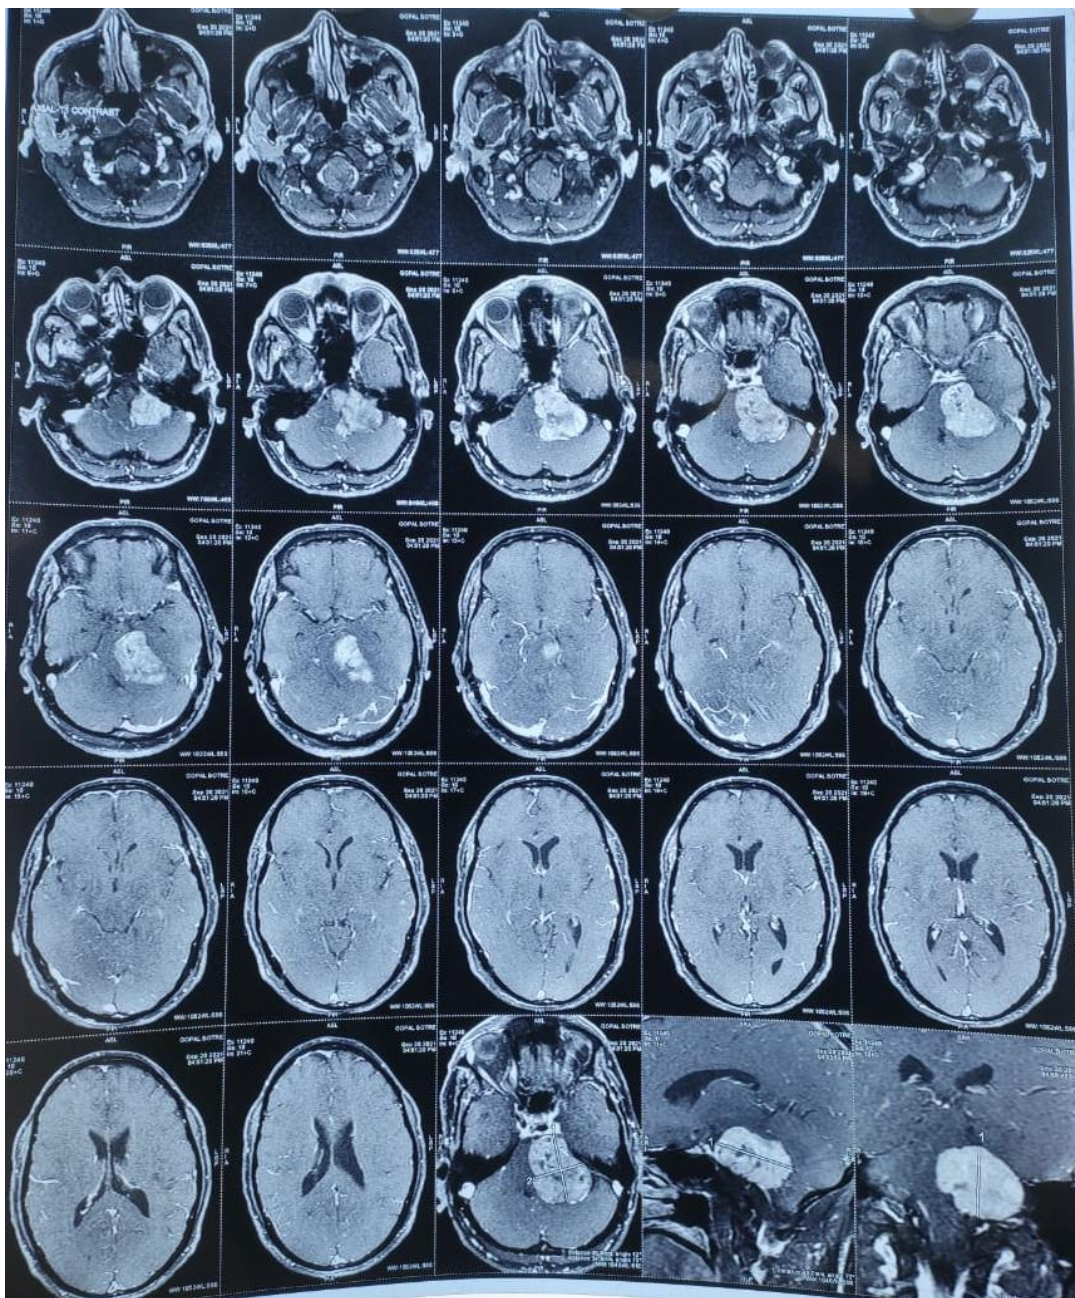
Preoperative MRI Scan
